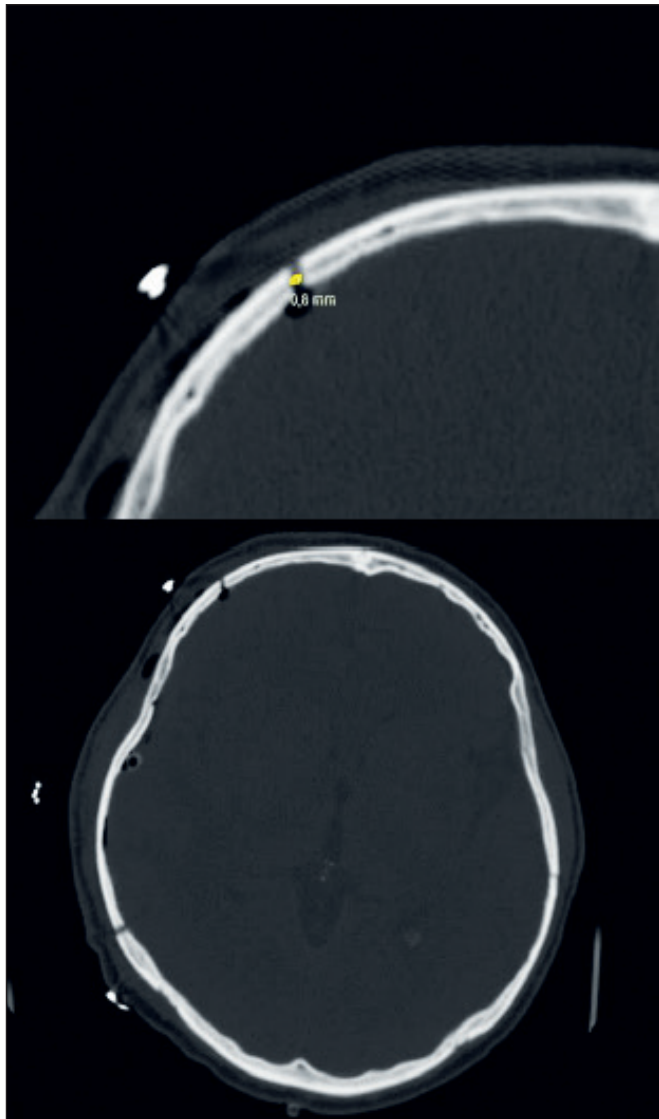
The measurement of the distance between the graft-bone border in the axial section non-contrast brain CT after the cranioplasty surgery of the patients.
